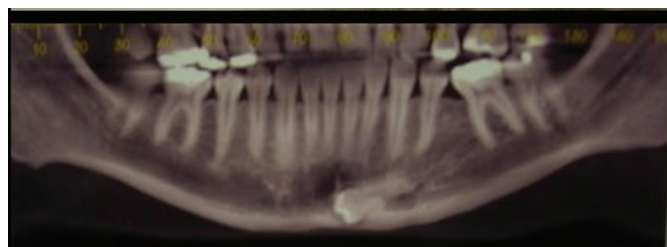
Panoramic slice of a cone beam computed tomography scan that reveal an impacted mandibular left premolar.
